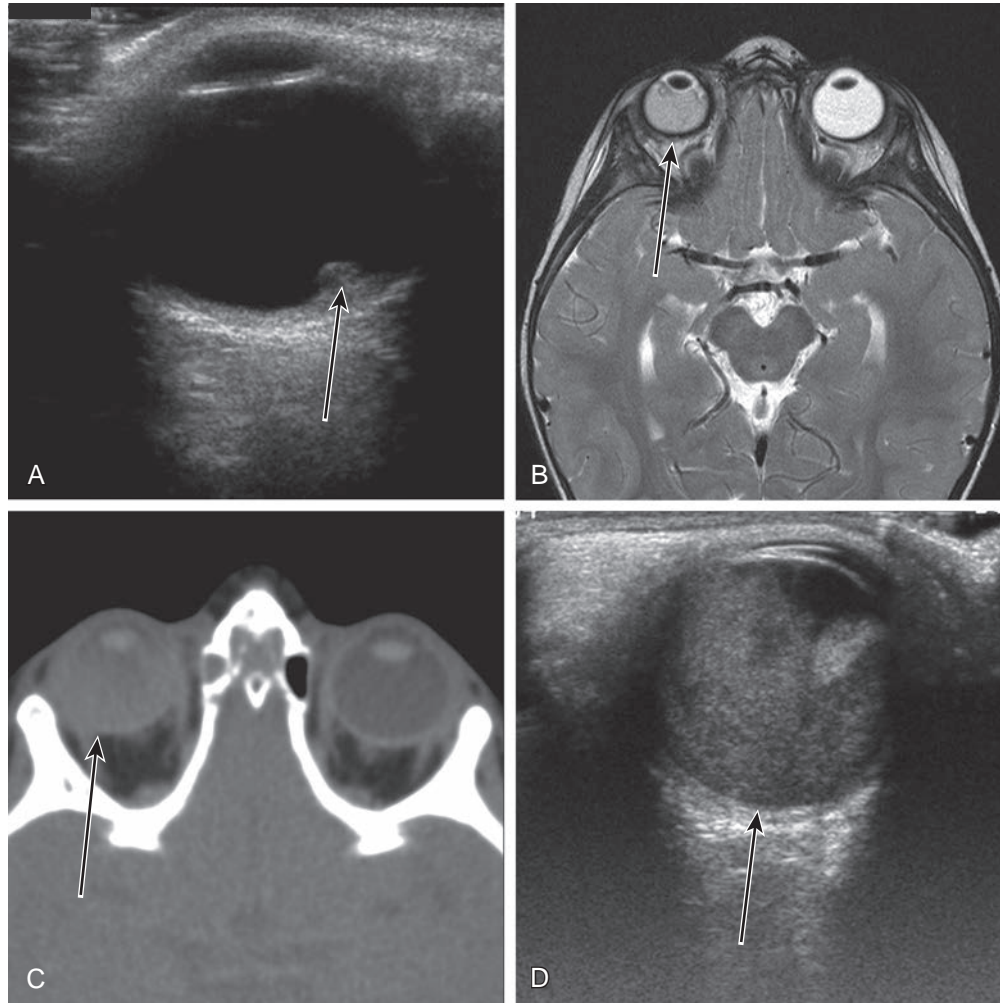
Coats disease. (A) Ultrasound shows a hyperechoic mass in the posterior vitreous (*arrow*) without posterior acoustic shadowing. (B) Axial T2-weighted MRI shows intermediate signal within the right vitreous (*arrow*) in keeping with proteinaceous exudate. (C) Unenhanced orbital CT demonstrates homogenous hyperattenuation of the right globe (*arrow*) and a normal left globe. (D) Ultrasound of the right eye shows hyperechogenicity within the vitreous (*arrow*) and a more focal area of increased echogenicity anteriorly.
